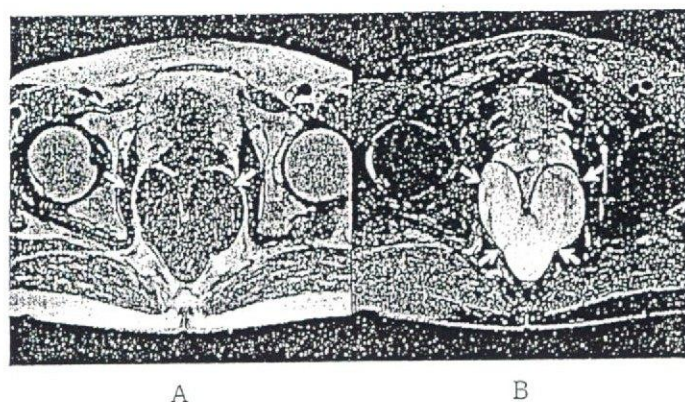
骨盤部 MRI 検査：T1強調像で低信号(A), T2強調像で高信号であった (B).
